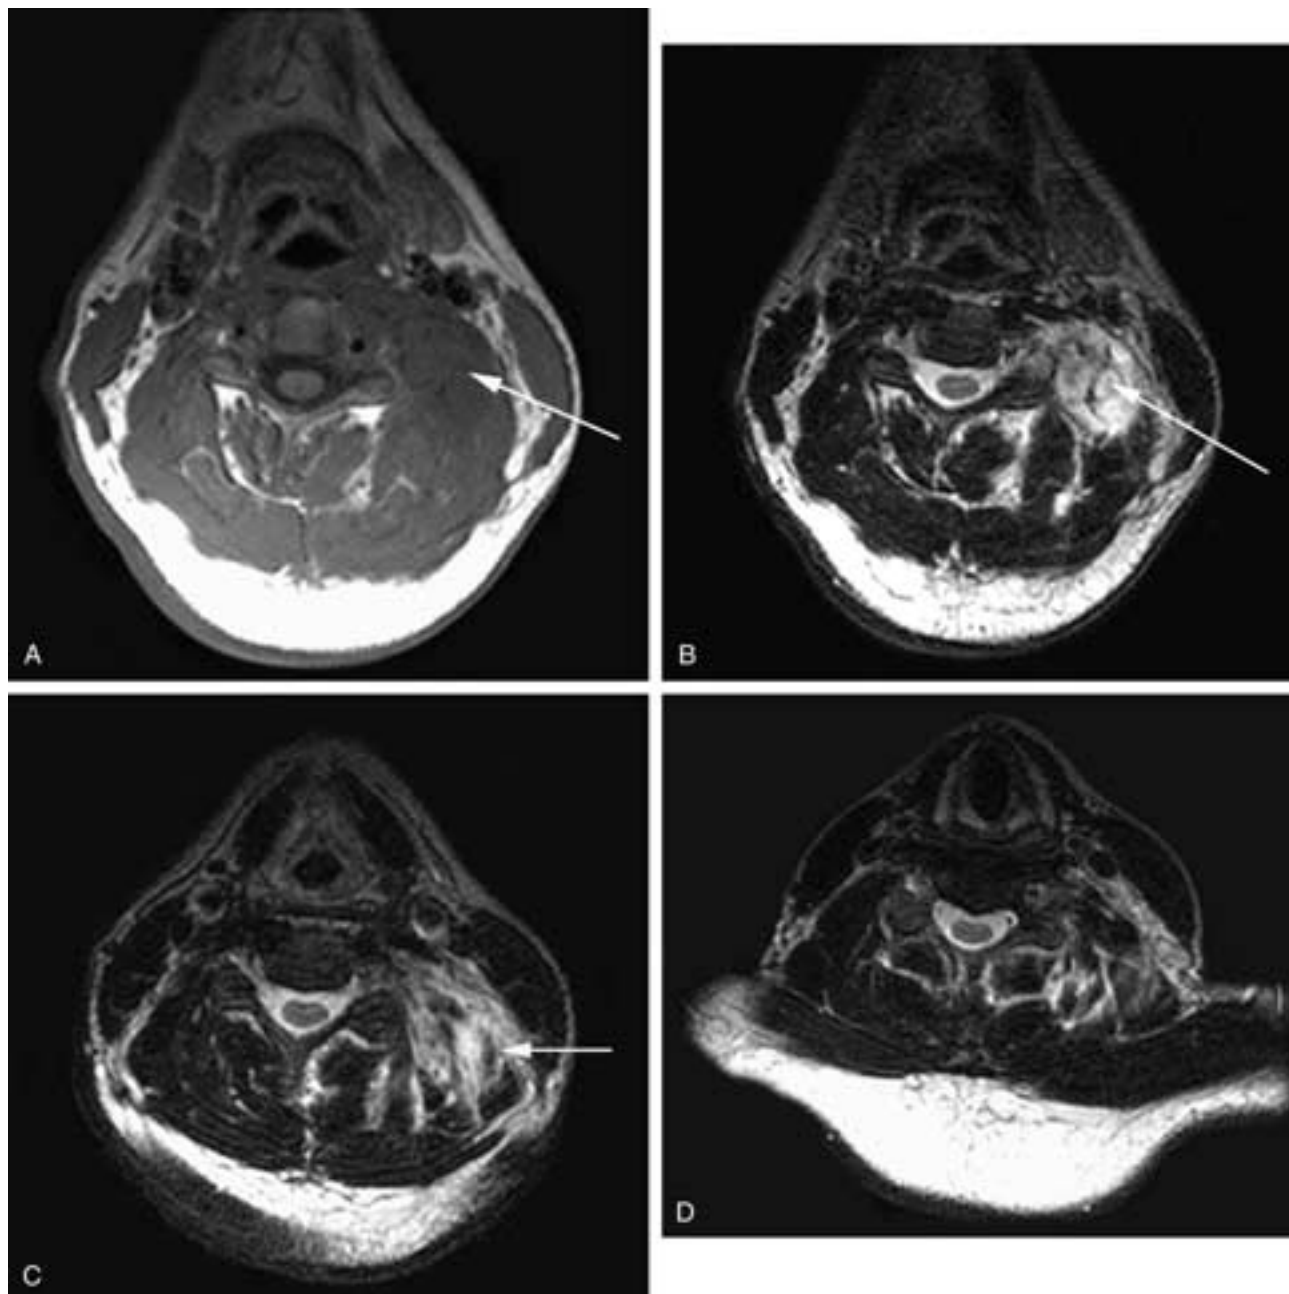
Same patient as in Figure 41-30. MR images obtained 1 week after onset of neck pain. In A, a T1-weighted MR image, there is a poorly defined soft-tissue mass (*arrow*), while in B, a T2-weighted MR image, the mass (*arrow*) has signal voids that could be interpreted as either vascular or fibrous in origin. There is also edematous-type high signal intensity in the immediate region. In C, a T2-weighted MR image more caudal in the neck, there is fullness and high signal intensity in the muscles and adjacent soft tissues (*arrow*). In D, a T2-weighted MR image obtained 1 month after onset, the mass and edema in the paraspinal muscles have decreased. This patient had myositis ossificans.
